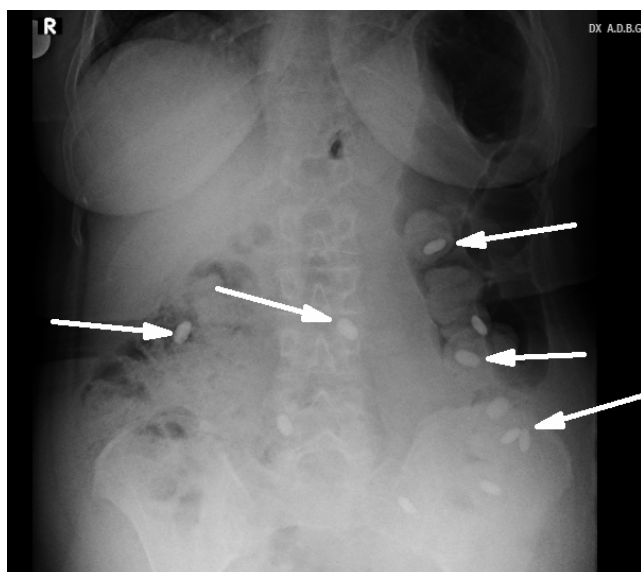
Hyperdense foreign bodies on standing plain abdominal radiography
